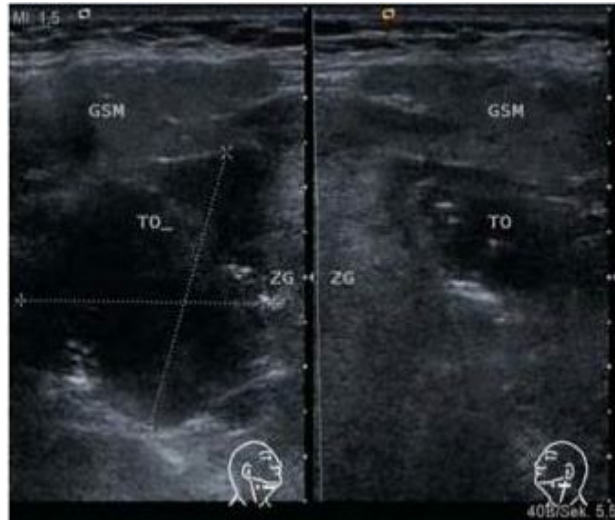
Image from atlas of the head and neck ultrasound shows right peritonsillar abscess compared to normal left tonsil.
